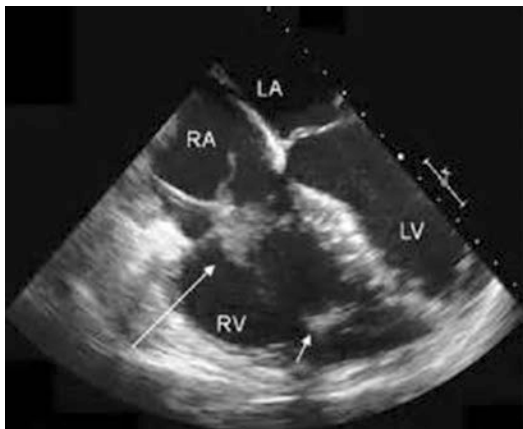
2D echocardiogram demonstrating pacemaker lead and tricuspid valve endocarditis
